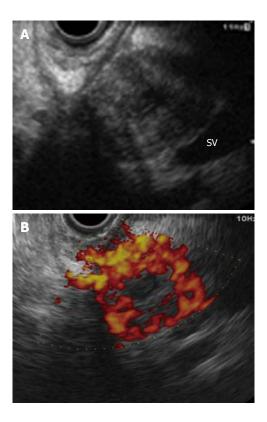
Metastatic pancreatic cancer from renal cell carcinoma. A: EUS shows a heterogeneous hypoechoic mass with a central necrotic area at the head of the pancreas; B: Contrast-enhanced Doppler EUS shows a hypervascular mass. SV: Splenic vein.
